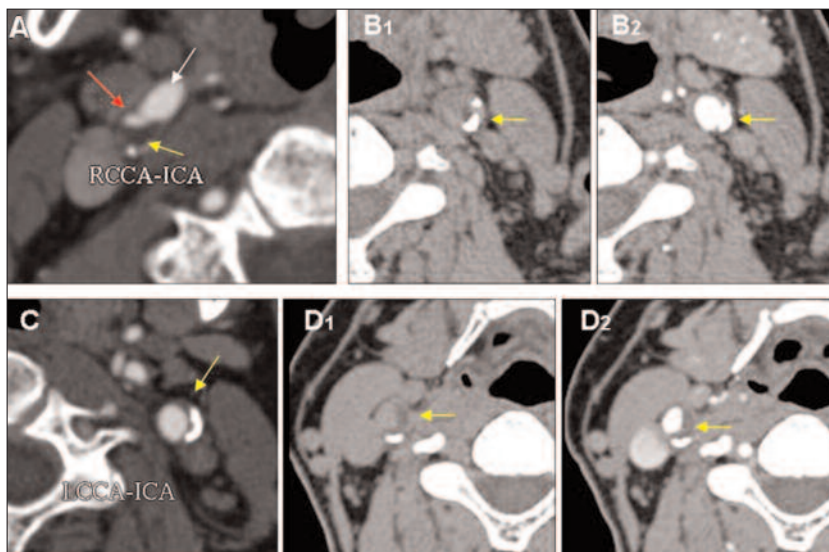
Characteristics of carotid plaque on axial CTA source image of carotid artery.
